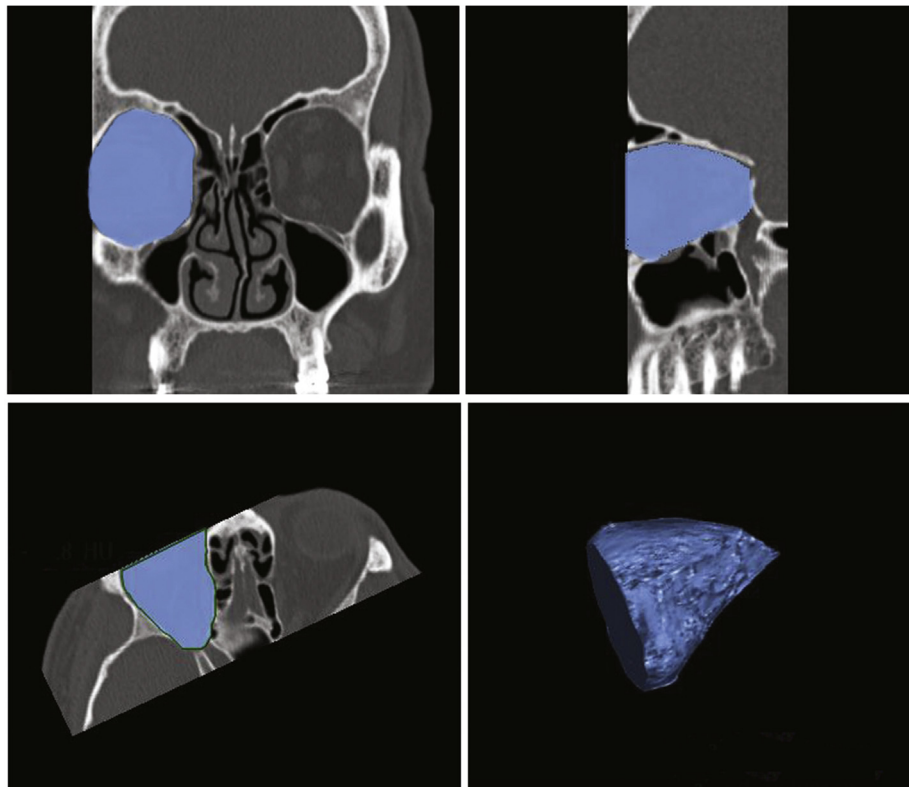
Limits of the normal orbital volume for CT measurements (see text for details).
